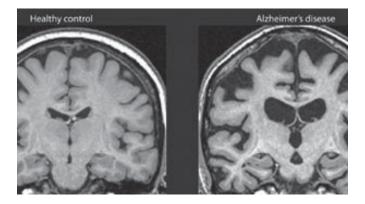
MRI Brain of Alzheimers Disease
